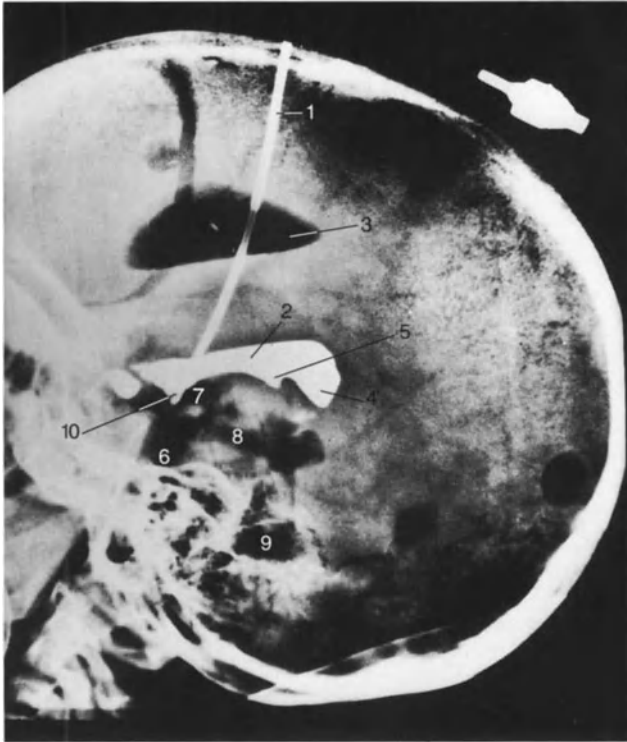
Stereotaxic, transventricular, III ventriculostomy. A catheter (1) has been inserted into the III ventricle (2) through the right lateral ventricle (3). One notes the positive contrast media within the inferior III ventricle and, within the chamber, the suprapineal (4) and pineal (5) recesses. Gas may be seen within the pontine (6), interpeduncular (7), and ambient (8) cisterns as well as within the IV ventricle (9). The catheter tip (10), under X-ray control, was poked through the floor of the III ventricle and into the interpeduncular cistern, establishing a III ventriculostomy.
